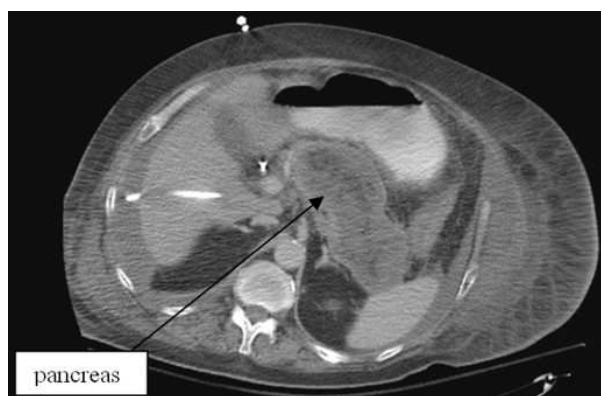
CT scan of the abdomen with contrast (Case #1).
